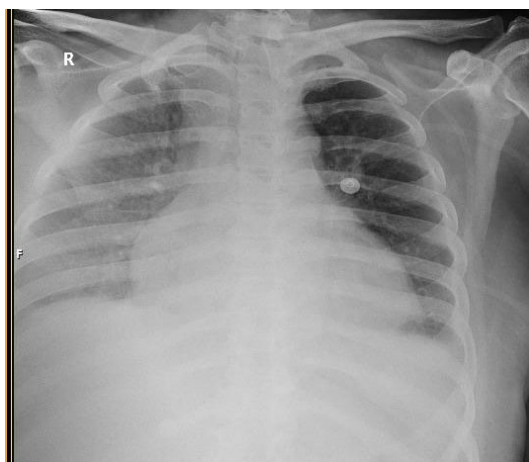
Case 3: Chest X-ray showing the jug sign secondary to massive pericardial effusion.
